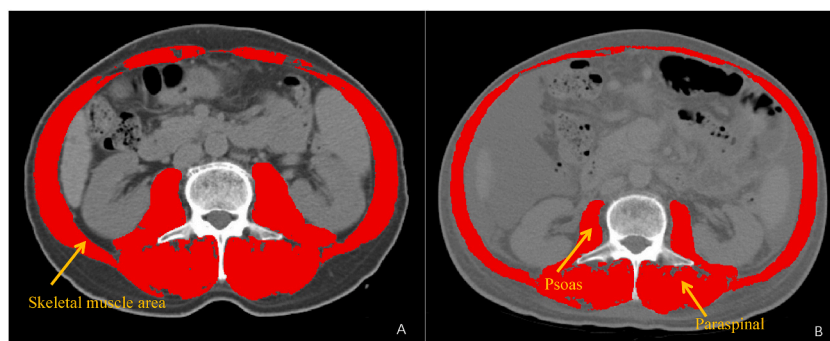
Computed tomography images of a 60-year-old male. He was diagnosed as cirrhosis caused by chronic infection of hepatitis B virus, who died for acute-on-chronic liver failure and hepatocellular carcinoma about 4 years after baseline. The axial abdominal CT scan (third lumbar vertebra) of the patient without sarcopenia (A) at baseline and with sarcopenia (B) 4 years later are compared (SMA: 133.5 cm^2 vs. 105.8 cm^2 , SMI: $49.04 \text{ cm}^2/\text{m}^2$ vs. $38.87 \text{ cm}^2/\text{m}^2$). Skeletal muscle area is highlighted in red.
